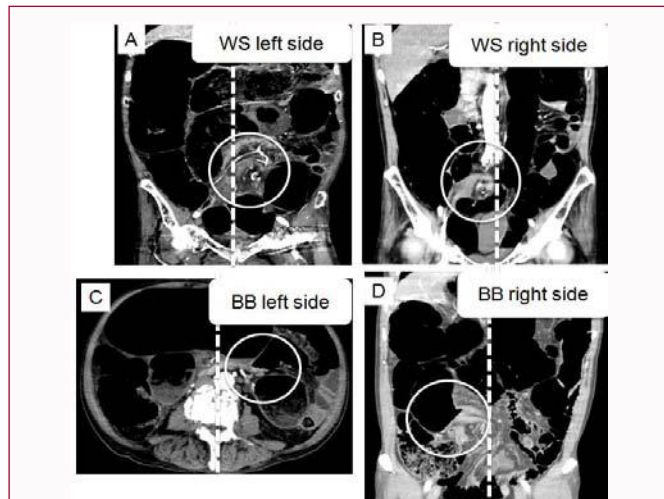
Positional relationship of whirl sign (WS) and bird's beak sign (BB) in abdominal CT. WS placed in left side (A) and right side (B) in abdominal CT findings. BB placed in left side (C) and right side (D) in abdominal CT findings.
